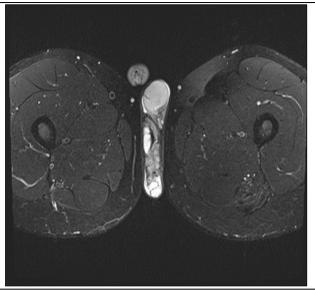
MRI axial and coronal images showed cystic changes manifested by low and high signal intensities on short and long TE sequences, respectively, with no contrast uptake on postcontrast series
